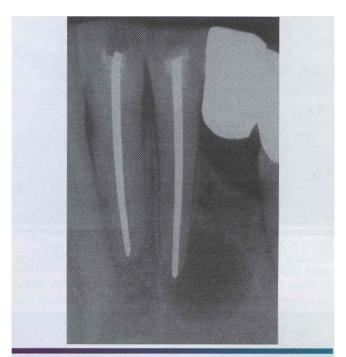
• Periapical cyst. Well-circumscribed radiolucency intimately associated with the apex of the mandibular central incisor. Note the loss of lamina dura in the area of the lesi on.
